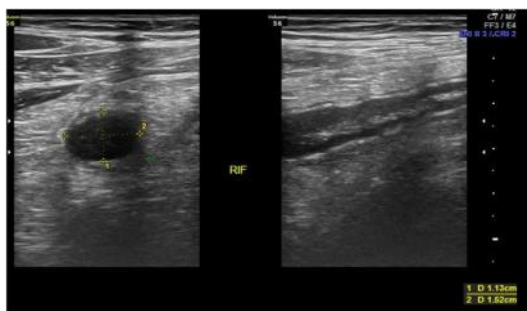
(E,F). E. Transverse & longitudinal sonogram of the right lower quadrant in a 27 years old adult male shows a dilated, thickened non-compressible appendix with an outer diameter of 11 mm suggestive of acute appendicitis. F. Transverse color Doppler image shows dilated appendix with increased flow in the wall (Grade 5).
